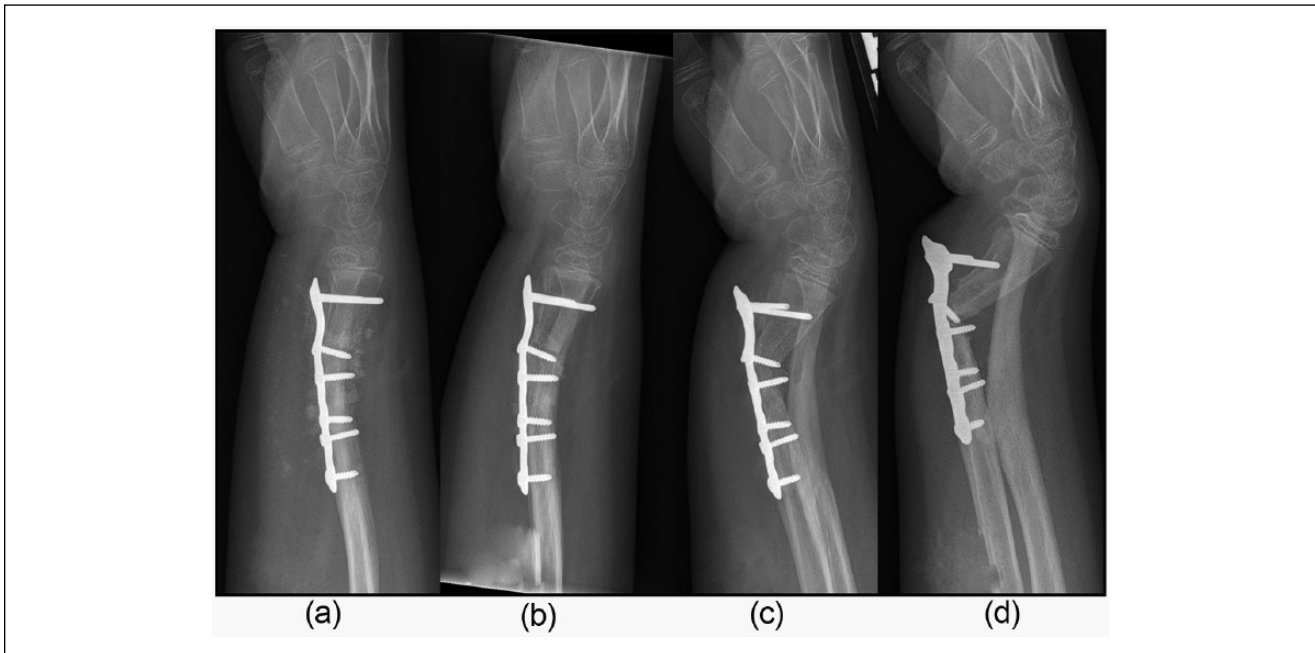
Sequence of events following an attempted open reduction internal fixation. (a) Radiographs at the time of surgery, (b) 1 month, (c) 3 months, and (d) 10 months, demonstrated a gradual loss of reduction. The patient returned to his native country between 3 and 10 months, which accounted for the loss of follow-up.
